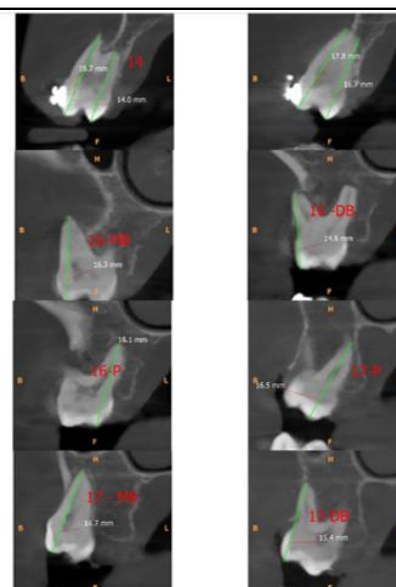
Post intrusion CBCT for Buccolingual inclination of maxillary posteriors (Inclination measured on coronal section using an angle formed between a line passing through the long axis of the tooth to a vertical line parallel to the mid-sagittal plane)
